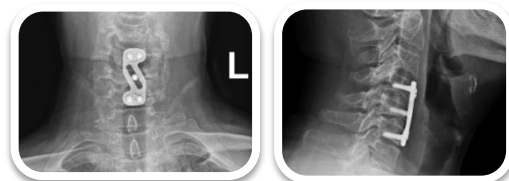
Follow-up X-ray three months after surgery
